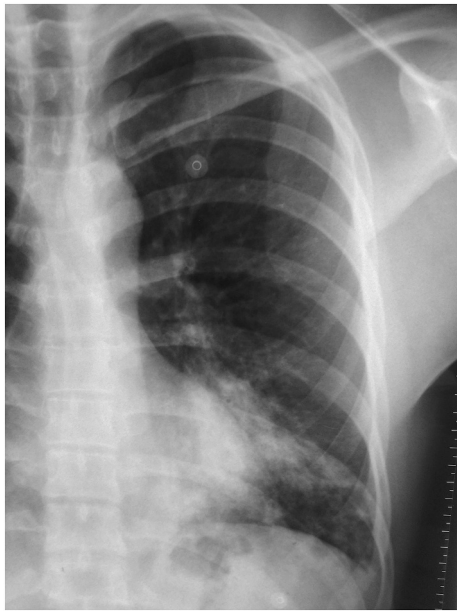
Chest x-ray showing haziness in left lower zone.
